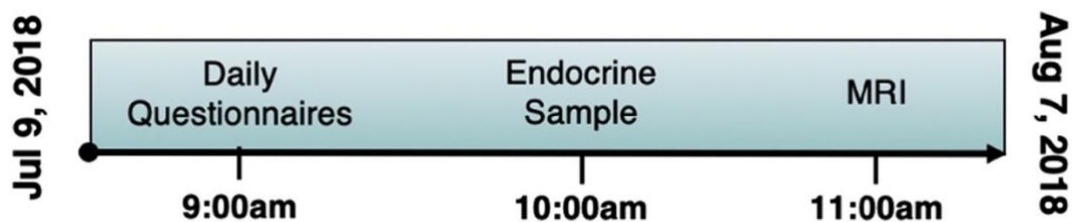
Timeline of data collection for the 30 experiment sessions. Endocrine and MRI assessments were collected at the same time each day to minimize time-of-day effects.
